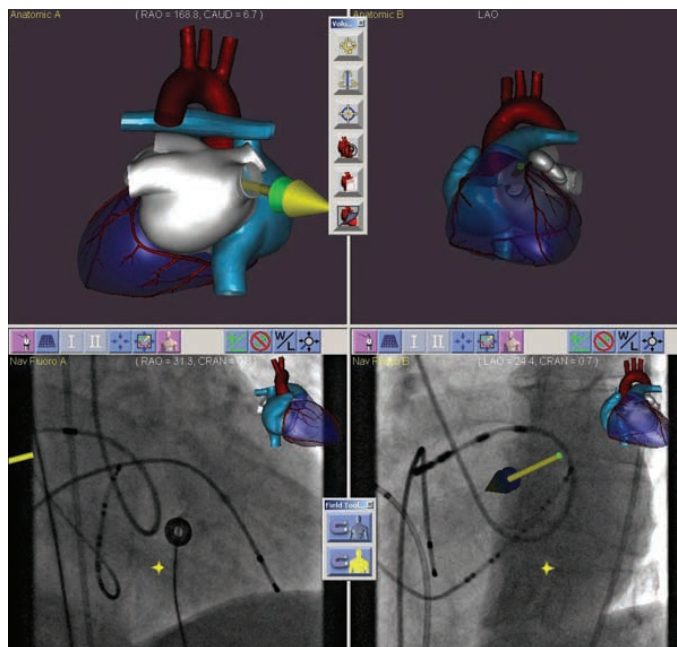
Retrograde access to the right inferior pulmonary vein (RIPV). Having gained access via the aortic valve and through the mitral valve to the left atrium, presets in the Navigant system have been used to gain access to the PV. Left above is an area indicating the vector used by the preset to access the RIPV while below are RAO and LAO fluoroscopic images taken over from the X-ray system.
